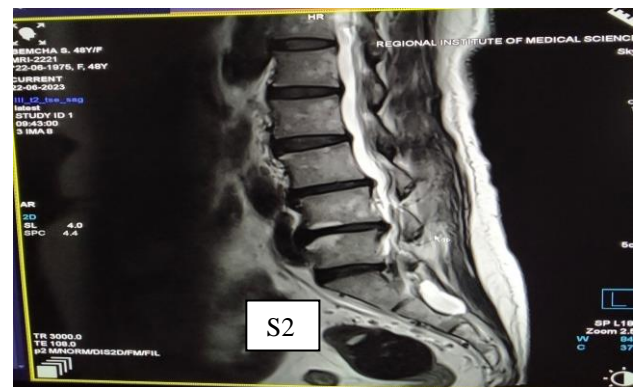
MRI LS spine sagittal view showing a single tarlov cyst in the S2 region of her spine.
